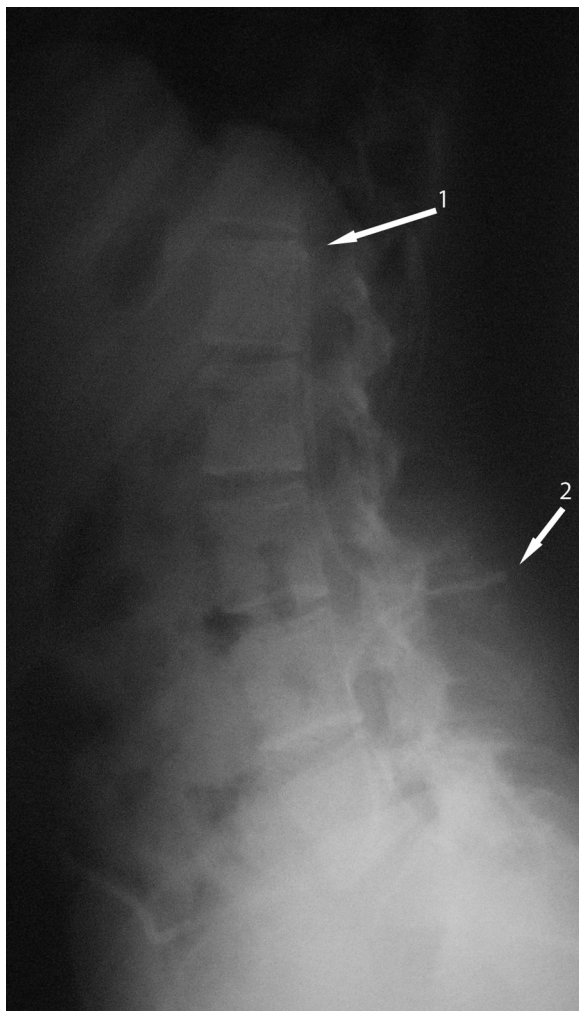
A lumboperitoneal catheter entering the sac posteriorly and extending from the L3–L4 interspinous level (Arrow 2) to the L1 level (Arrow 1), as seen on an X-ray image.
